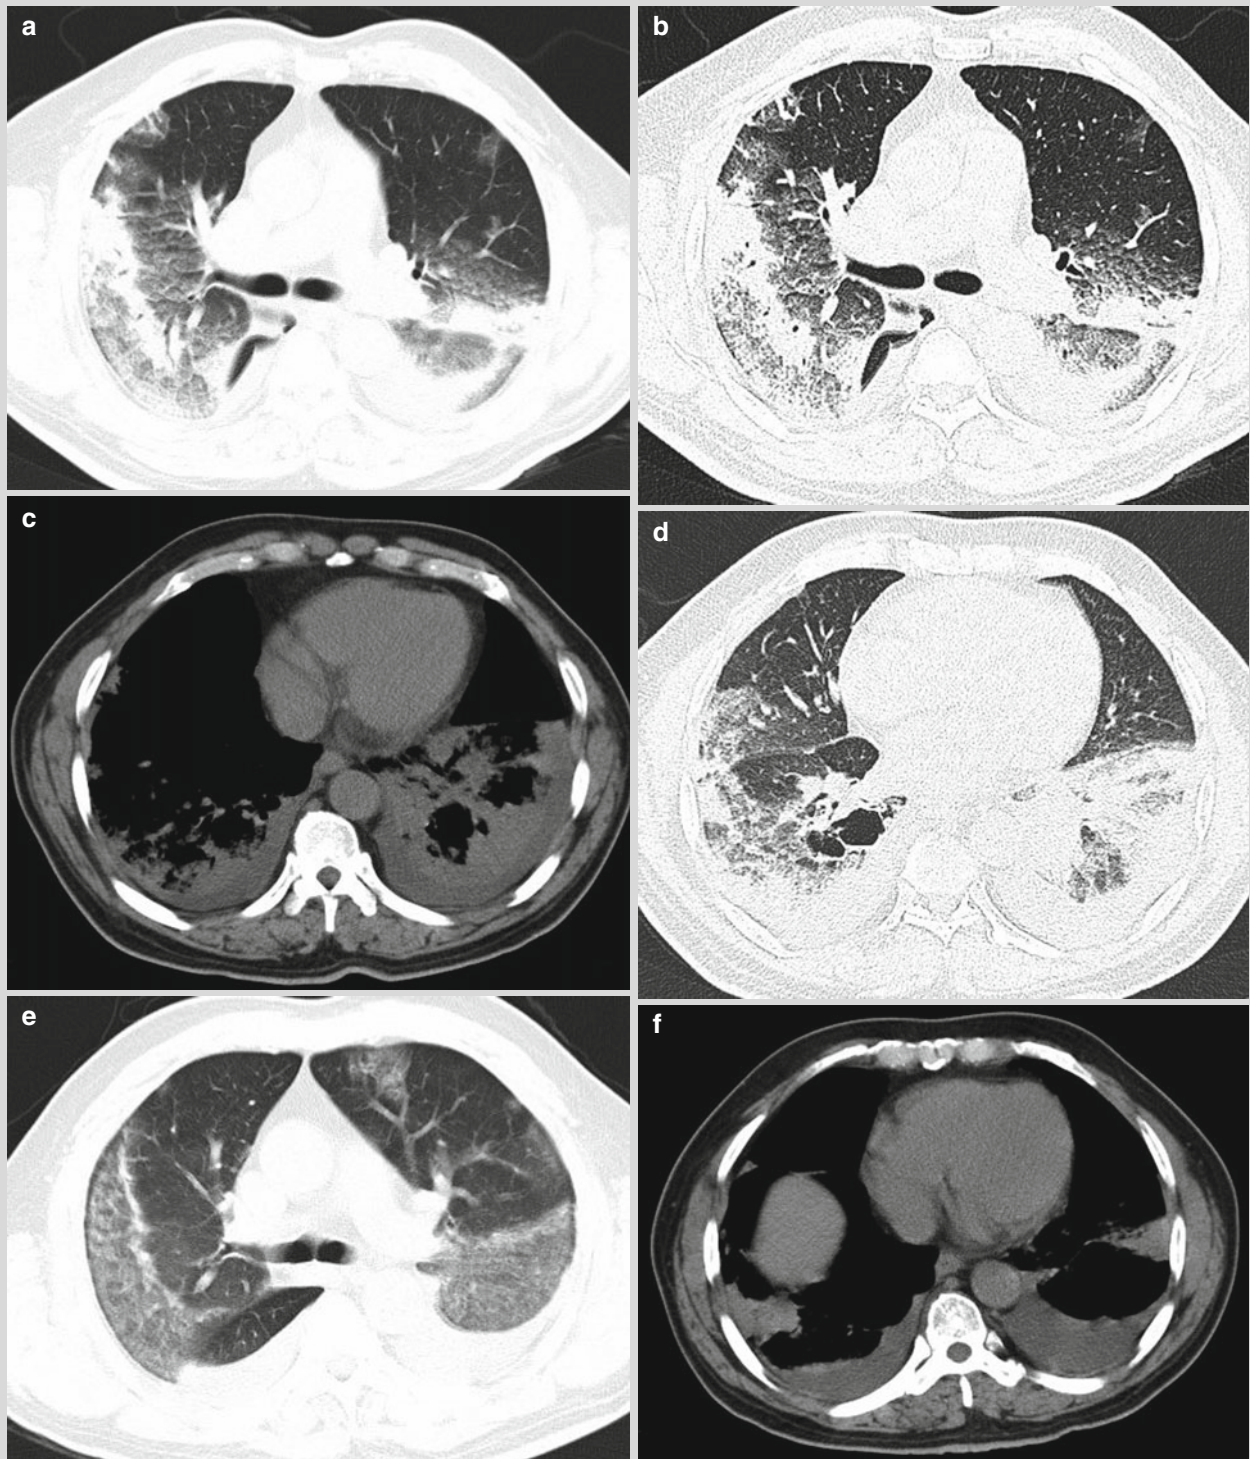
CT scan showed multiple flakes of ground glass like and grid like high density opacities in both lungs, with air bronchogram within some lesions (b as the 1 mm reconstructed image of the same layer of a) (a, b). Bilateral pleural effusion in a small quantity (c). The basal segment of the right lower lung was shown with an irregular air containing cyst, with a little gas-fluid level (d). Reexamination after 4 days treatment, the lesions in the lungs were obviously absorbed (e). Bilateral pleural effusion progressed (f).
